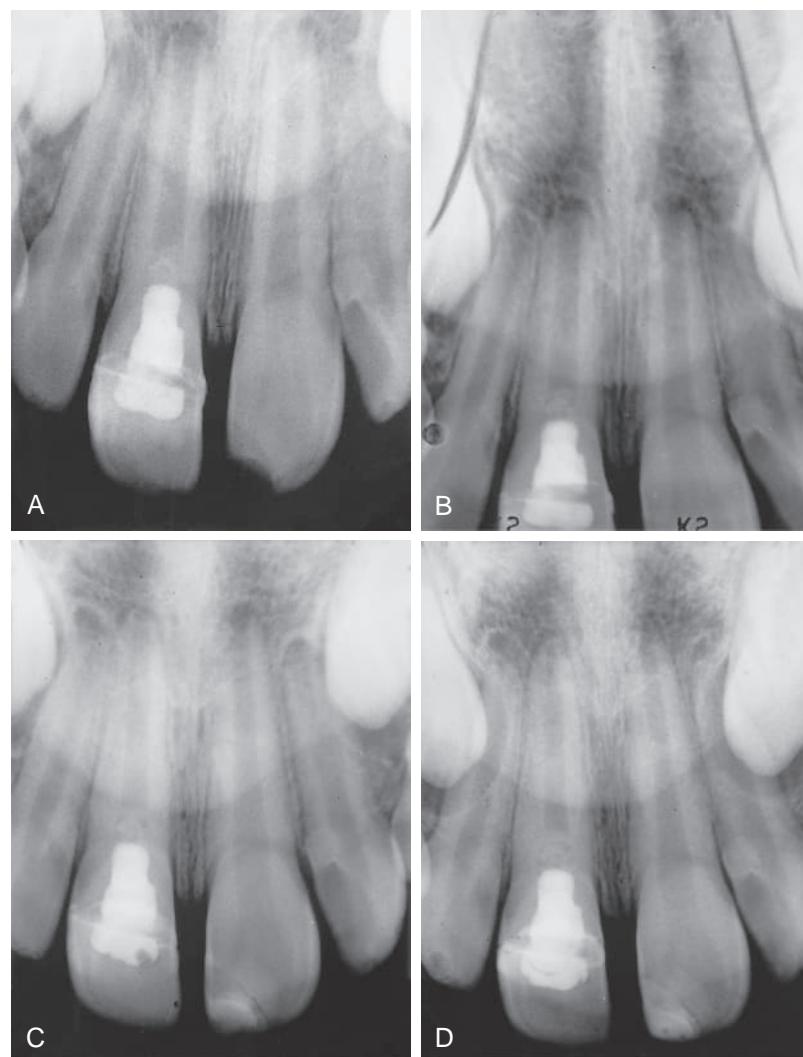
(A) Radiographic appearance of the restored maxillary right central incisor 10 days after a complicated crown fracture occurred and the calcium hydroxide pulpotomy was performed. A fragment restoration was also used to restore the Class II fracture of the maxillary left central incisor at this same appointment, but after this radiograph was obtained. (B) This radiograph, made 7½ weeks after the pulpotomy, shows evidence of a calcified bridge developing at the level of the pulpal amputation. (C) Eight months after initial treatment, it appears that root development is progressing normally for both maxillary central incisors. (D) Root completion has been achieved on both maxillary central incisors 20 months after the original injury. The root canals exhibit normal anatomic configuration.
